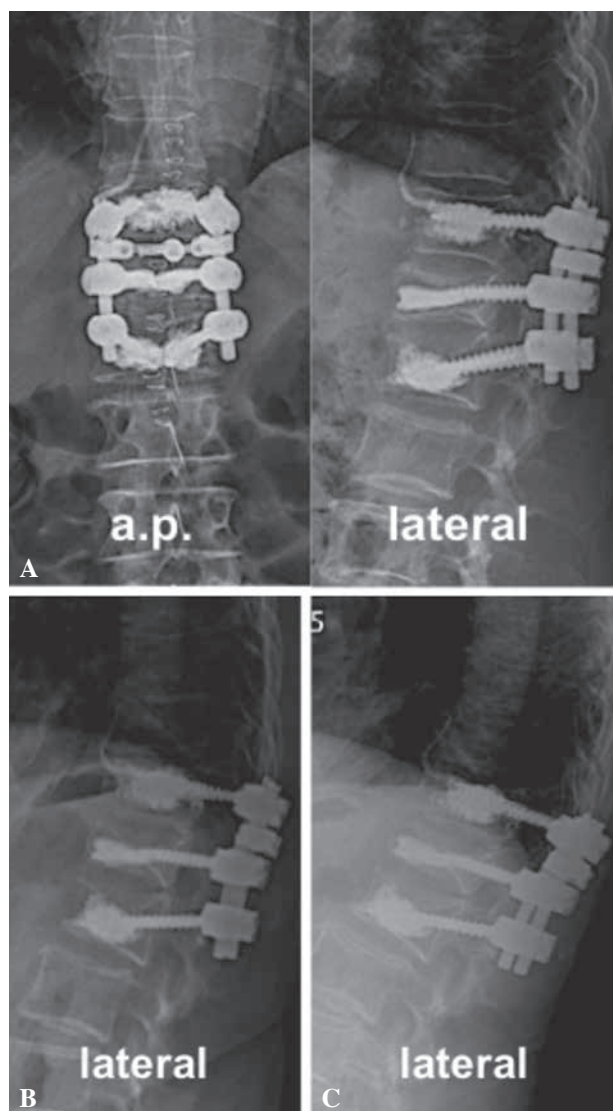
Conventional X-rays of the 75 yo female patient in erect position after posterior cement augmented screw-and-rod instrumentation and kyphoplasty of the L1 vertebra at 3 days post-op (A), 6 months (B) and 1 year after surgery (C).
